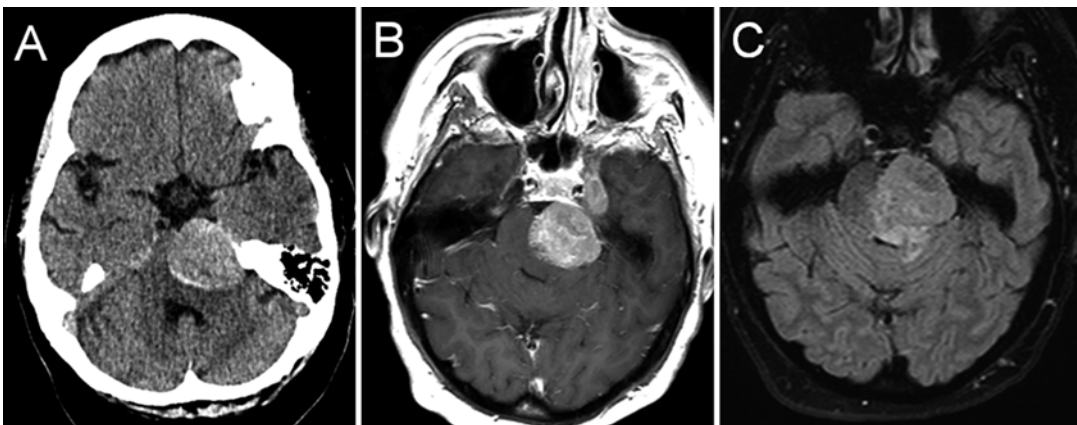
Radiographic features of CNS melanoma. Axial non-contrast head CT shows a hyperdense mass lesion on the left displacing the pons (a). Axial T1-weighted
